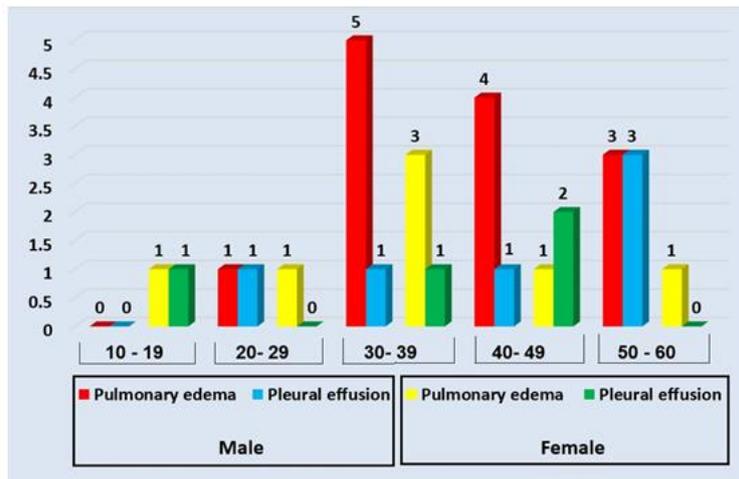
Distribution of Chest X-Ray finding according to age & Sex
